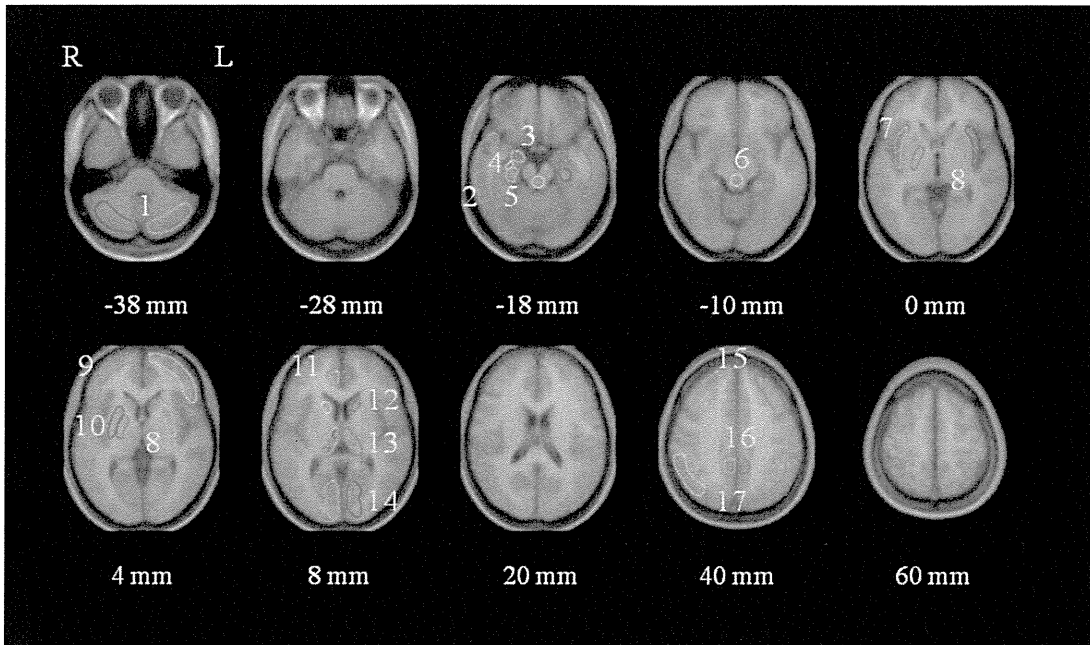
VOIs drawn on the anatomically standardized MR images averaged for all subjects. Z = -38, -28, -18, -10, 0, 4, 8, 20, 40, 60 mm parallel to the anterior commissure and posterior commissure (AC-PC) line in the MNI template brain. L denotes left side of the brain; R denotes right side; 1, cerebellar cortex; 2, lateral
